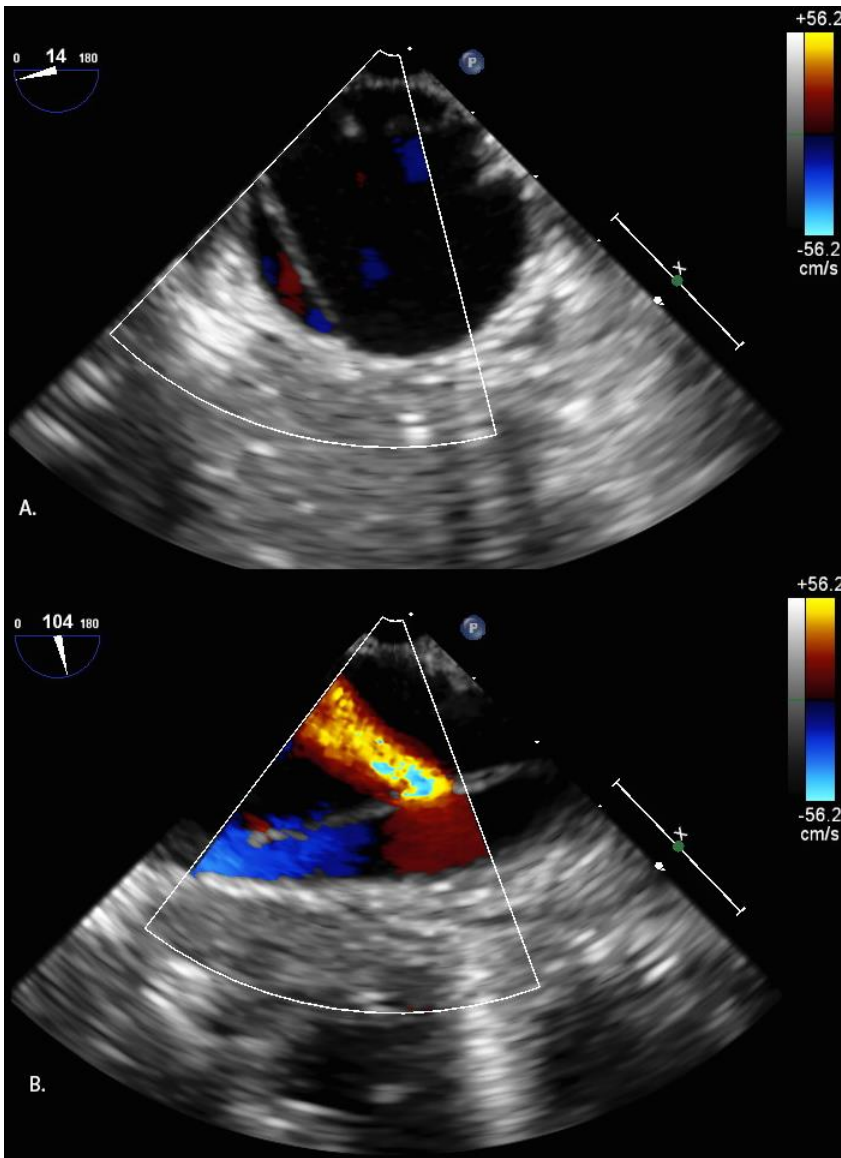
Descending thoracic aortic dissection. Mid-esophageal descending aorta short-axis view (14°)[View 25](top) shows the dissection flap along the left side of the image. The mid-esophageal descending aorta long-axis view (104°)[View 26](bottom) shows the orthogonal view of the dissection flap, with color Doppler allowing visualization of communication between the true and false lumen.
